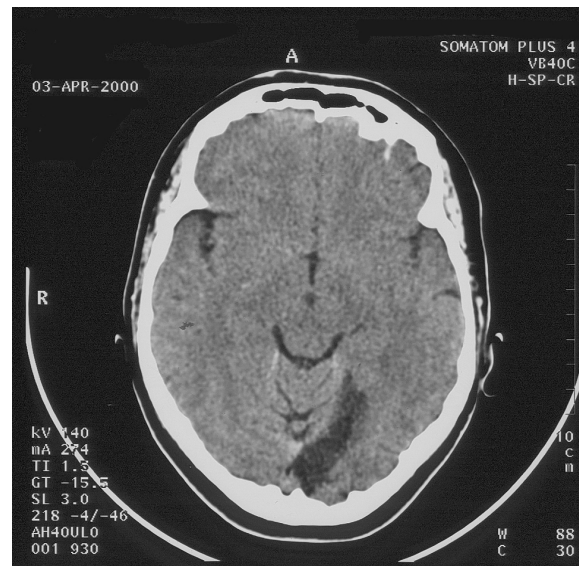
CT of the brain of patient I.M. from April 2000. The left occipital lobe shows a large defect can be seen.
